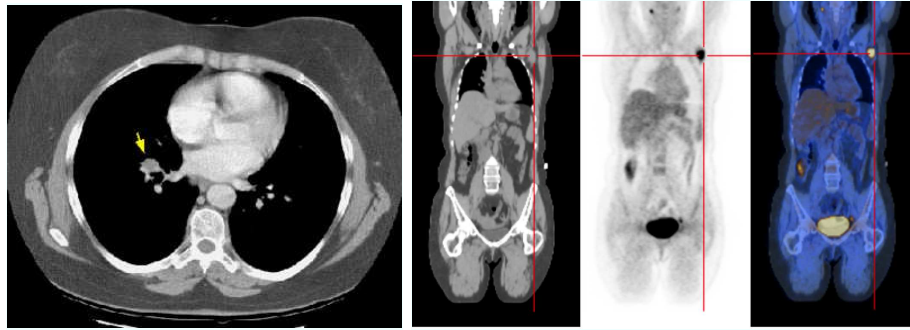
Above: CT (L) and PET (R) scan images.
